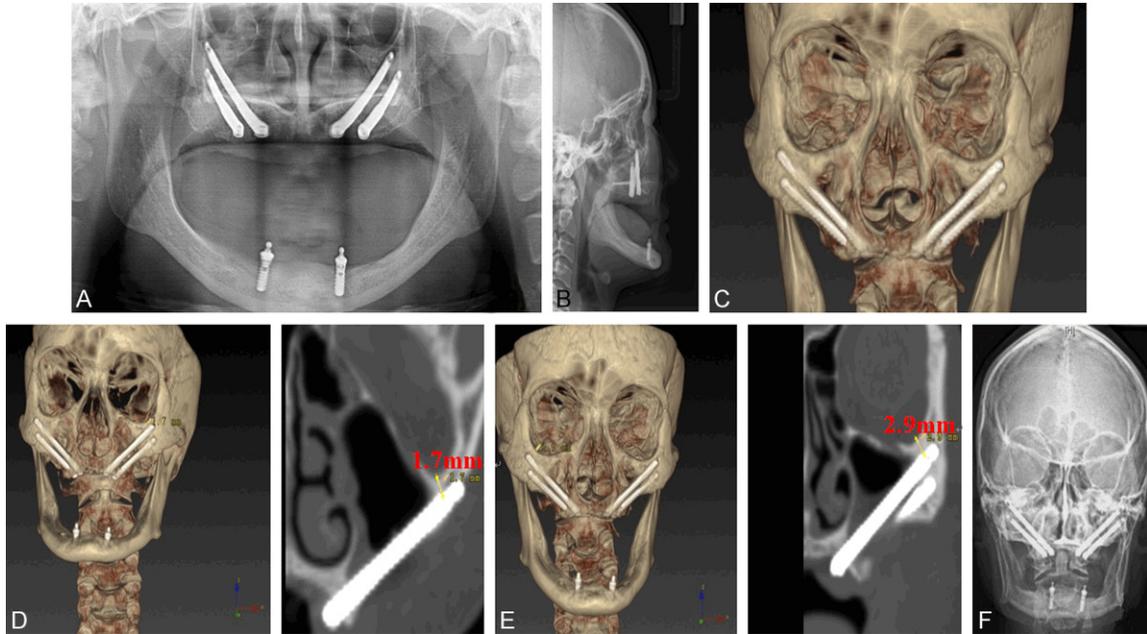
Patient I A-C, F: Post-surgical cephalogram, orthopantomograms and CT showing ideal distribution of four ZIs; D: The minimum distance between left orbital margin and anterior ZI was 1.7 mm from 3D model; E: The minimum distance between left orbital margin and anterior ZI was 2.9 mm from 3D model.
